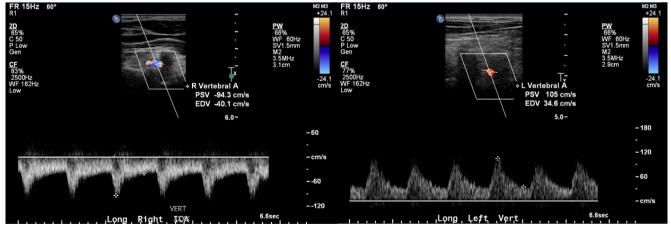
Retrograde flow noted in the right vertebral artery with a PSV of 94 cm/s and EDV of 40 cm/s. The left vertebral artery demonstrates antegrade flow with a PSV of 105 cm/s and EDV of 35 cm/s. When the direction of flow is not clear in the vertebral artery, it is advised to document the CCA in split screen, with red representing blood flow towards the brain, and then angling and sliding the probe laterally and posteriorly to image the vertebral artery without changing any of the Doppler parameters. The vertebral vein will be seen anterior to the vertebral artery and may appear pulsatile. It is important not to confuse the two vessels. Both will pass through the transverse foramina of the cervical spine, and it may be easier to distinguish the two by looking for the origin of the vertebral artery off the subclavian artery
